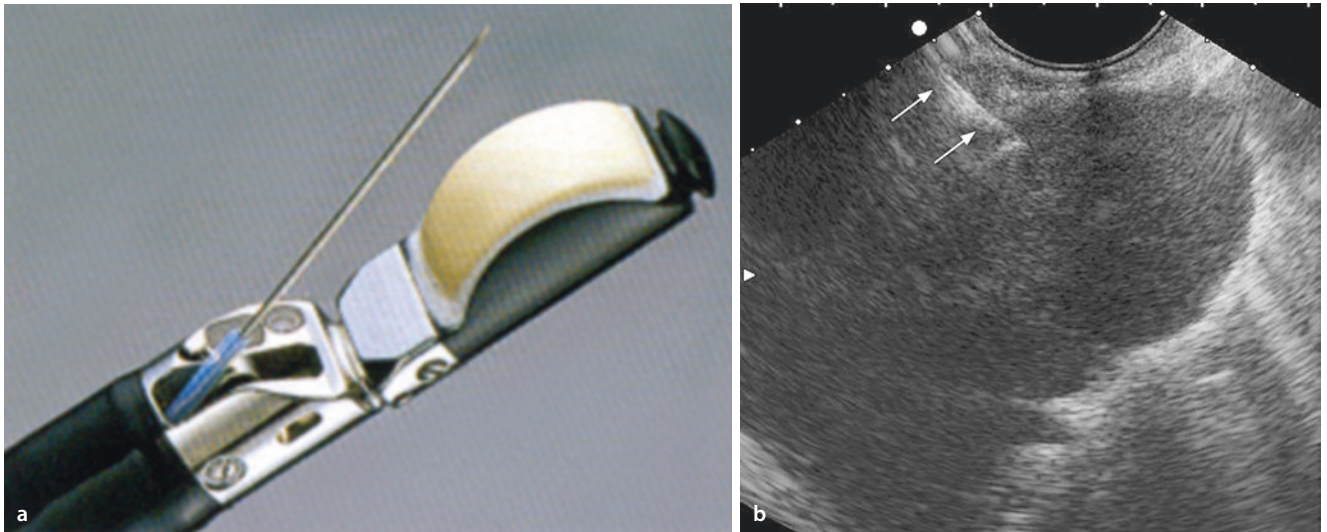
Transesophageal puncture. a Longitudinal probe with puncture unit (Hitachi). b Paraesophageal hypoechoic tumor mass in the dorsal mediastinum. The puncture needle is easily recognizable (arrows). Cytology indicated small-cell bronchial carcinoma
